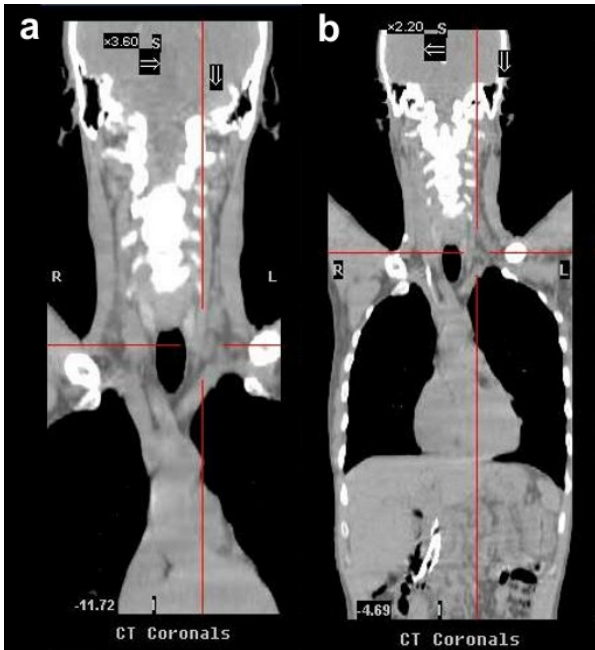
CT scans of Patient #1 before (a.) and after (b.) chemotherapy. CT scans do not demonstrate presence of supraclavicular metastasis in Patient #1.
